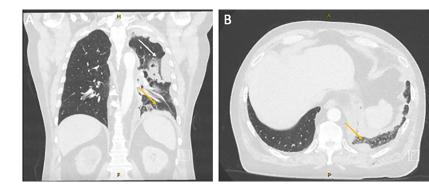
A CT chest abdomen and pelvis in lung window demonstrating left-sided pleural thickening in the hemithorax (white arrow) and hemidiaphragm (yellow arrows) characteristic of mesothelioma. (A) Coronal view. (B) Axial view. CT: computed tomography.
